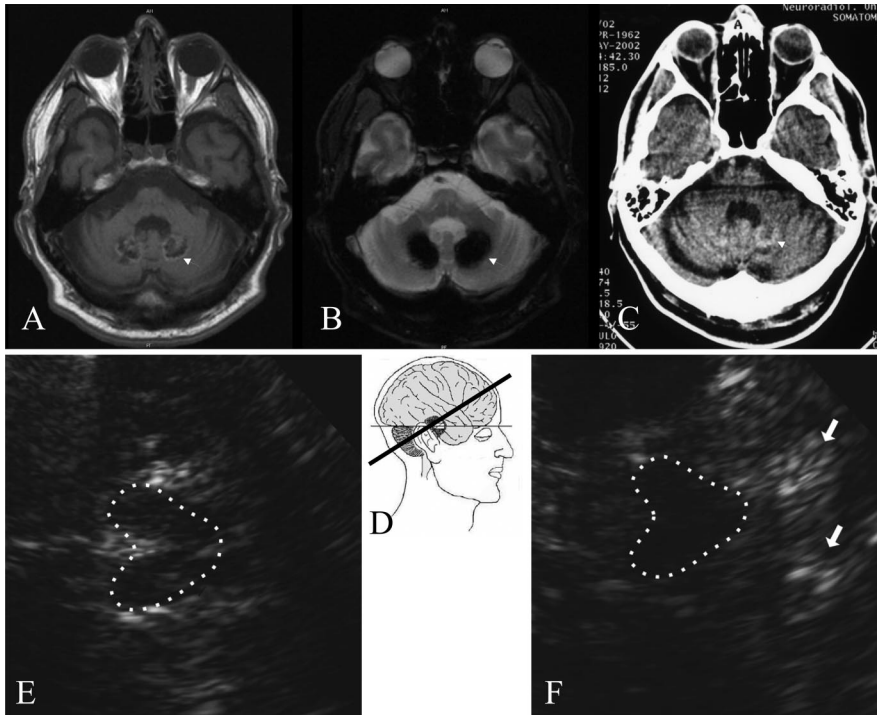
MRI revealed T1 hypointensities with hyperintense rim (A) with corresponding hyperdensity on CT (C) suggestive of a mixture of calcification and hemosiderin deposits. On T2 images (B) both regions are indistinguishable hypointense due to susceptibility effects. Transcranial sonography showed in the fourth-ventricular scanning plane (D) marked hyperechogenicity of the dentate nucleus (arrows) behind the mesencephalic brainstem (dotted lines) (F) compared to a control (E).*
